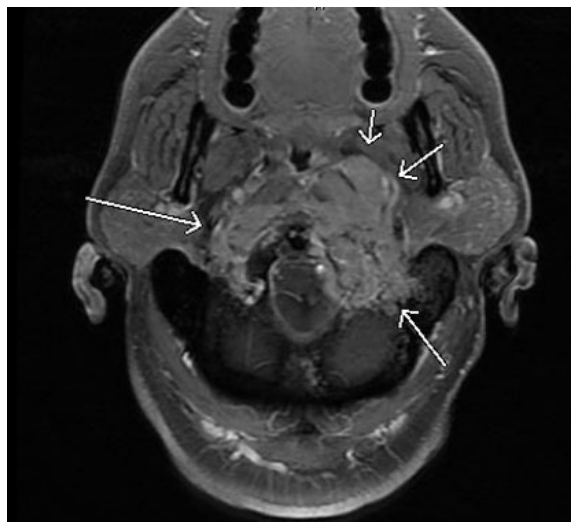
Preoperative axial computed tomography (CT) image of cervical spine demonstrating soft tissue mass.
